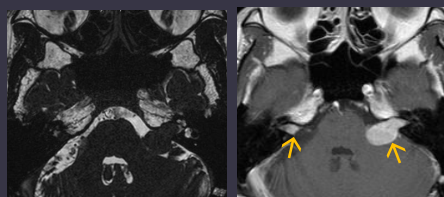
MRI T2 CISS (Left) & T1 + C (Right)
